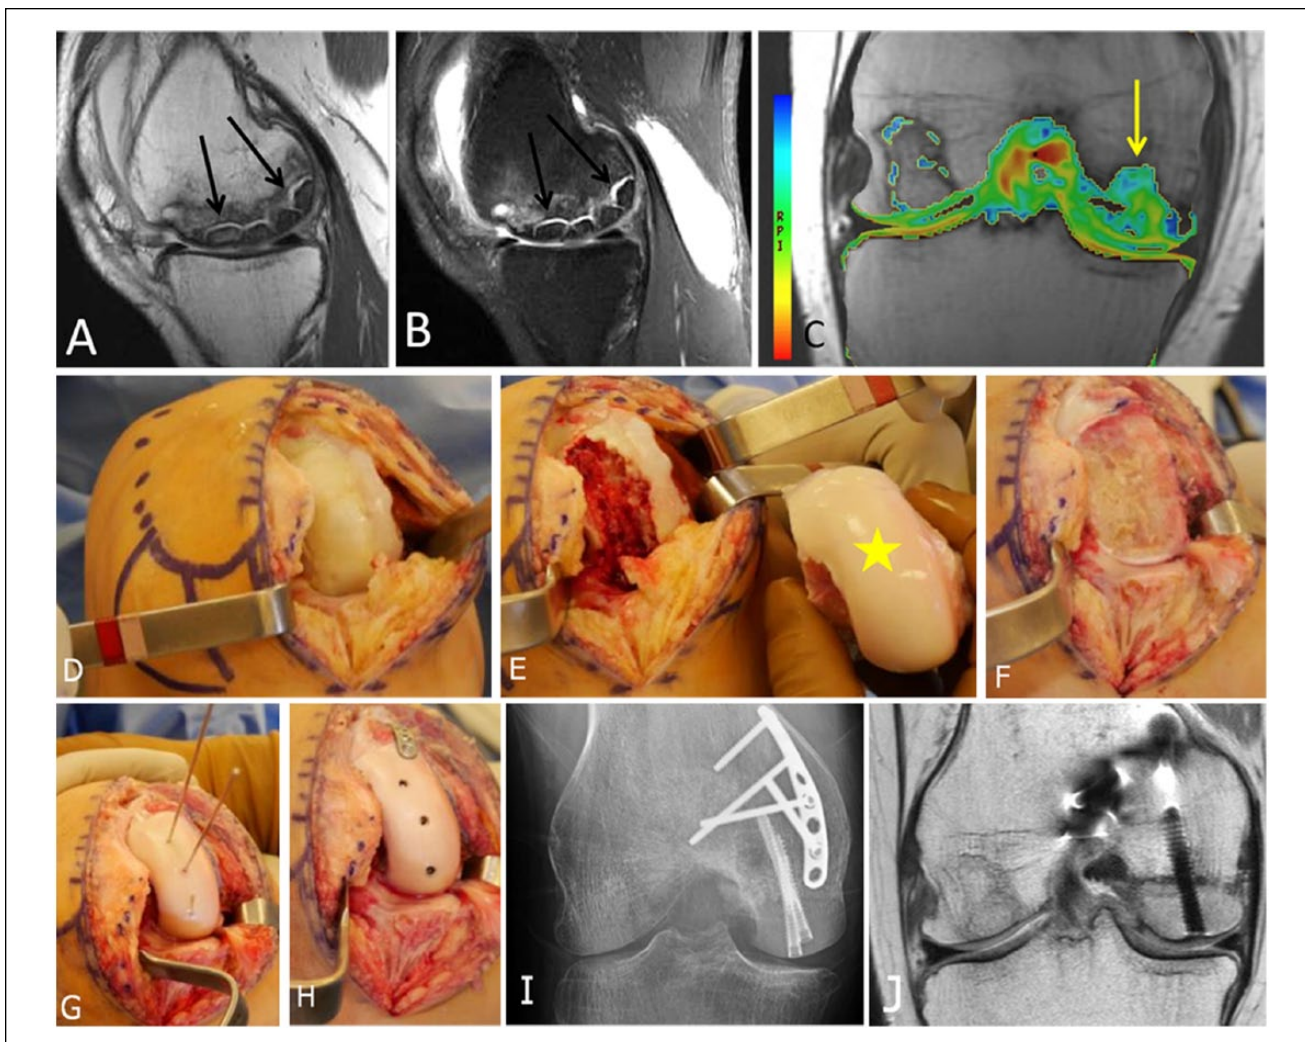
A 26-year-old female who had medial femoral condyle transplantation with matched fresh allograft. (A, B) Large areas of avascular necrosis is seen in both the sagittal (A) T1- and (B) fat-suppressed T2-weighted MRI (arrows). (C) Coronal T2 mapping MRI also shows prolongation of tissue relaxation times in the cartilage over the area of transplanted medial femoral condyle (arrow) compared to the lateral condyle. (D) Open arthrotomy of the knee is performed and the AVN of the medial femoral condyle is seen. The large area of AVN is debrided and seen in E. The matched femoral condyle is seen holding up to the defect (yellow star). (F) Free cut of the medial femoral condyle is performed. (G) The matched condyle is shaped to match the defect. Three wires are used to hold the condyle to the defect. (H) Three headless screws are inserted along with a small anti-shear plate to hold and fix the condyle transplantation. (I, J) Six months postoperative AP radiograph (I) and coronal proton density-weighted MRI (J) show metallic plate and screws transfixing the medial femoral condyle transplant in place, with evidence of successful incorporation and healing.
